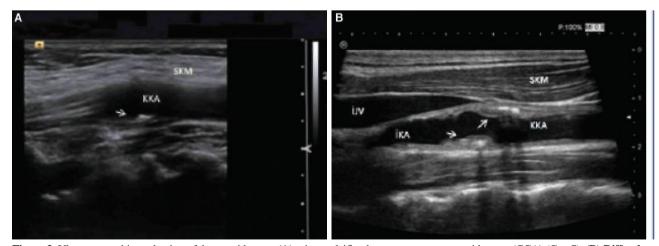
Ultrasonographic evaluation of the carotid artery (A) minor calcific plaque on common carotid artery (CCA) (Case7). (B) Diffusely thickened walls of CCA, and internal carotid artery (ICA), calcific plaques which caused luminal narrowing were seen (Case 5). SKM: Sternocleidomastoid muscle; JJV: Internal jugular vein
